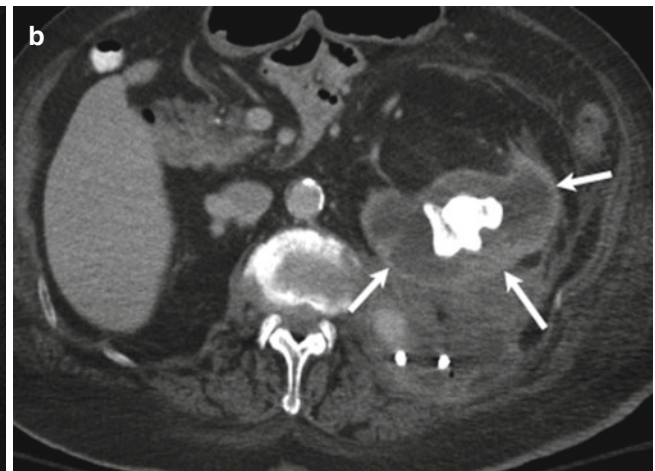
Xanthogranulomatous pyelonephritis. Scout CT view (a) shows a large left staghorn calculus. Axial images from contrast-enhanced CT (b, c) demonstrate a nonfunctioning, hydronephrotic
